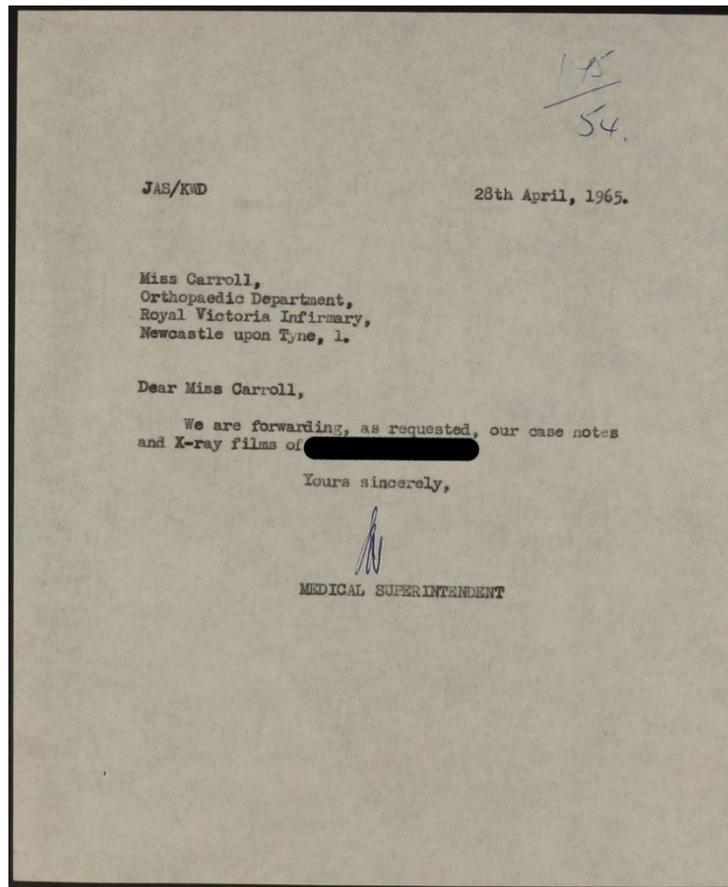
Letter demonstrating the transfer of x-ray films for a patient from Stannington Sanatorium to the Royal Victoria Infirmary, Newcastle-upon-Tyne, 1965 (HOSP/STAN/7/1/1/3062_01)
